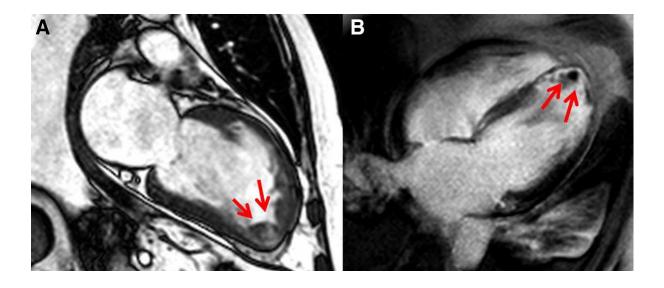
Patient with transmural anterior infarction with thrombus in the left ventricular apex (red arrows) in cine cardiac magnetic resonance imaging (A) and contrast-enhanced images (B).* Extracted from (29).
